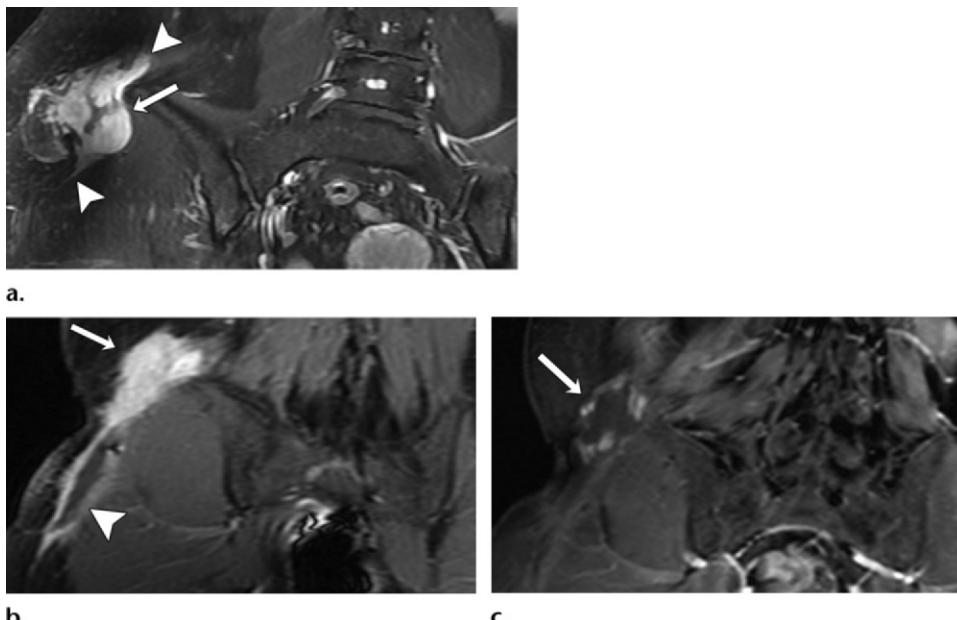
Positive treatment response to systemic therapy of a recurrent sporadic right flank DF in a 41-year-old woman after surgical resection. (a) Coronal contrast-enhanced fat-suppressed T1-weighted MR image (660/15) shows an irregular heterogeneously enhancing mass (arrow) abutting the right iliac crest. Note linear extension along the superior and inferior margins (arrowheads). (b) Coronal contrast-enhanced fat-suppressed T1-weighted MR image (300/2.5) 1 year after surgical resection shows a postsurgical seroma (arrowhead) with rim enhancement and recurrent desmoid tumor seen as a homogeneous enhancing mass (arrow) along the superior margin of the resection site. (c) Coronal contrast-enhanced fat-suppressed T1-weighted MR image (3.1/1.3) after 2 years of chemotherapy that included liposomal doxorubicin and sorafenib shows mild decrease in size and marked decrease in enhancement (arrow).
